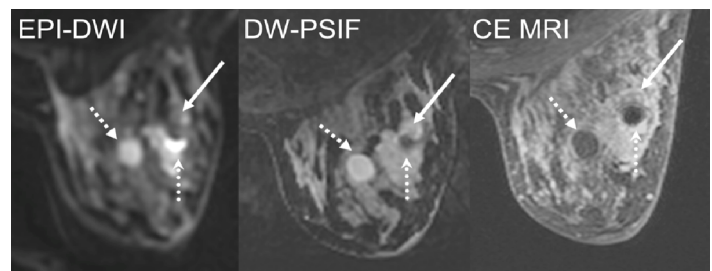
Patient volunteer with cyst (square dotted line), clip artifact (sphere dotted line), and IDC (solid arrow). DW-PSIF demonstrates improved lesion margin delineation and less clip artifact in comparison to the EPI-DWI image.
